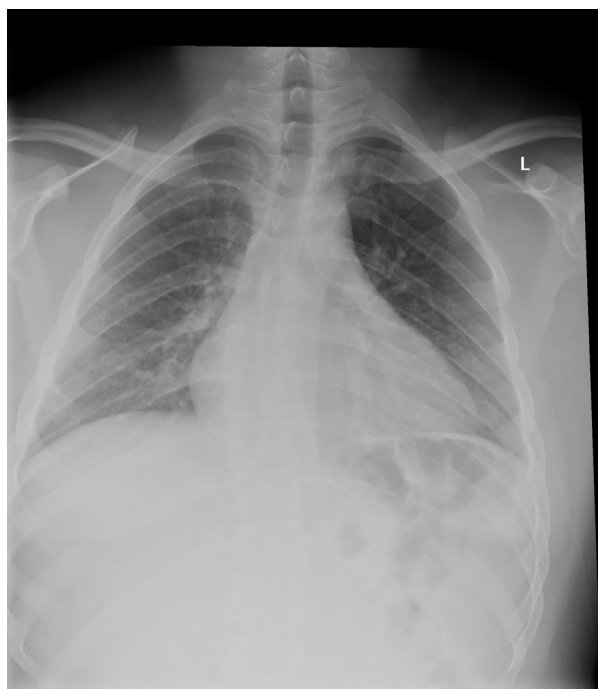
Posteroanterior chest x-ray with no pleural effusion or pneumothorax. The cardiomeastinal silhouette is mildly enlarged.
